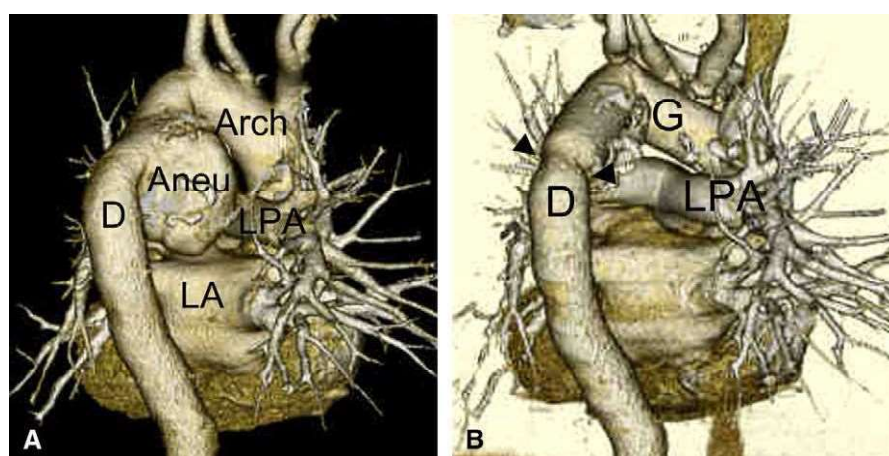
A, Preoperative 3-dimensional computed tomographic image in the dorsal view of a patient with a huge distal arch aneurysm; the diameter of the aneurysm was normalized behind the bifurcation of the pulmonary artery. B, Postoperative image of the same patient as in A. The arch and proximal descending aorta were completely replaced with a prosthesis (arrowhead) placed through a median sternotomy without any additional incision. Arch, Aortic arch; Aneu, aneurysm; LPA, left pulmonary artery; D, Descending aorta; LA, Left atrium. B, G, prosthetic graft.
